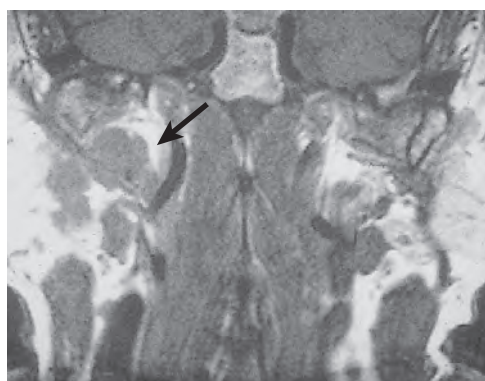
An axial view of a computed tomography scan showing a deep lobe parotid tumor (arrow).
